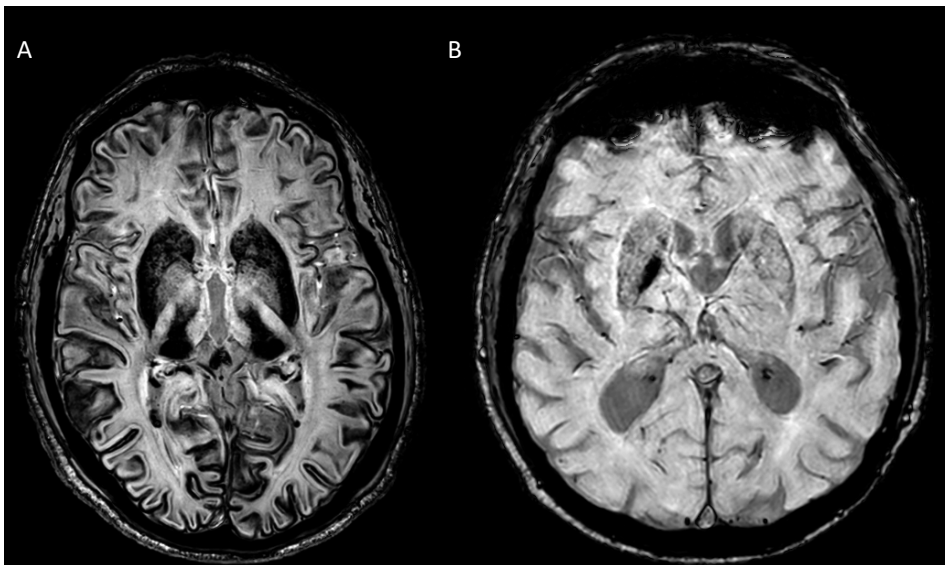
Brain MRI (a) Brain MRI of case 2 shows susceptibility artifact, consistent with iron overload seen in the thalamus, putamen, dentate nucleus both sides and to a lesser extent in the globus pallidus. The cerebral cortex is better aligned on the gradient sequence than normal, also consistent for iron overload. There is very minimal susceptibility artifact/iron overload seen high in the cerebellar cortex. (b) a brain MRI of a random person without iron deposition.
